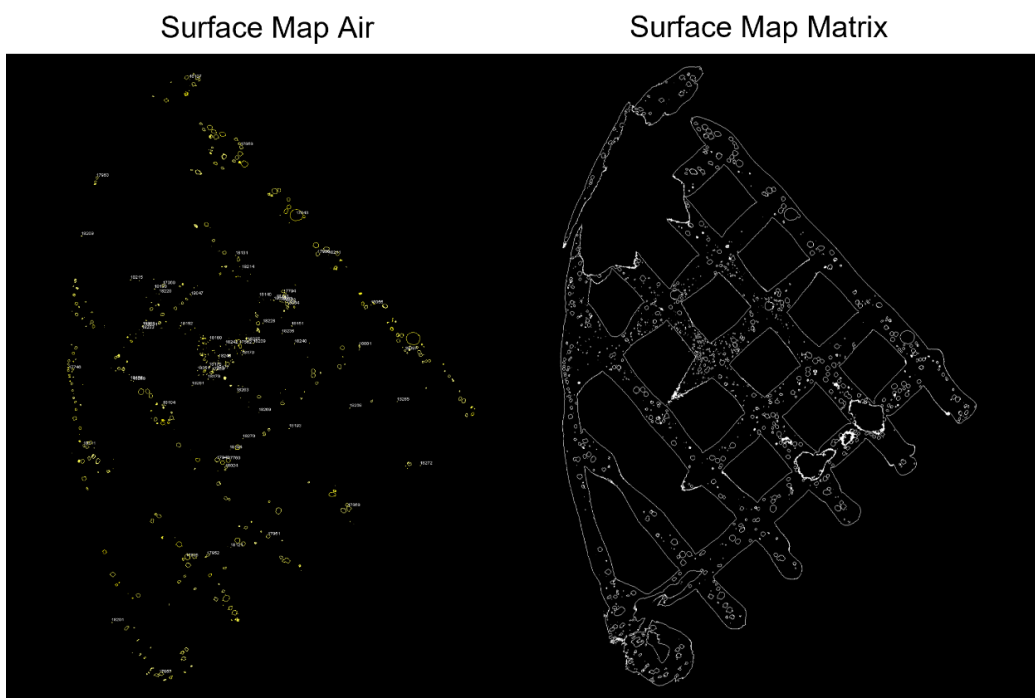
Exemplary images of surface maps of inserts obtained during image analysis of  $\mu$ CT images.
